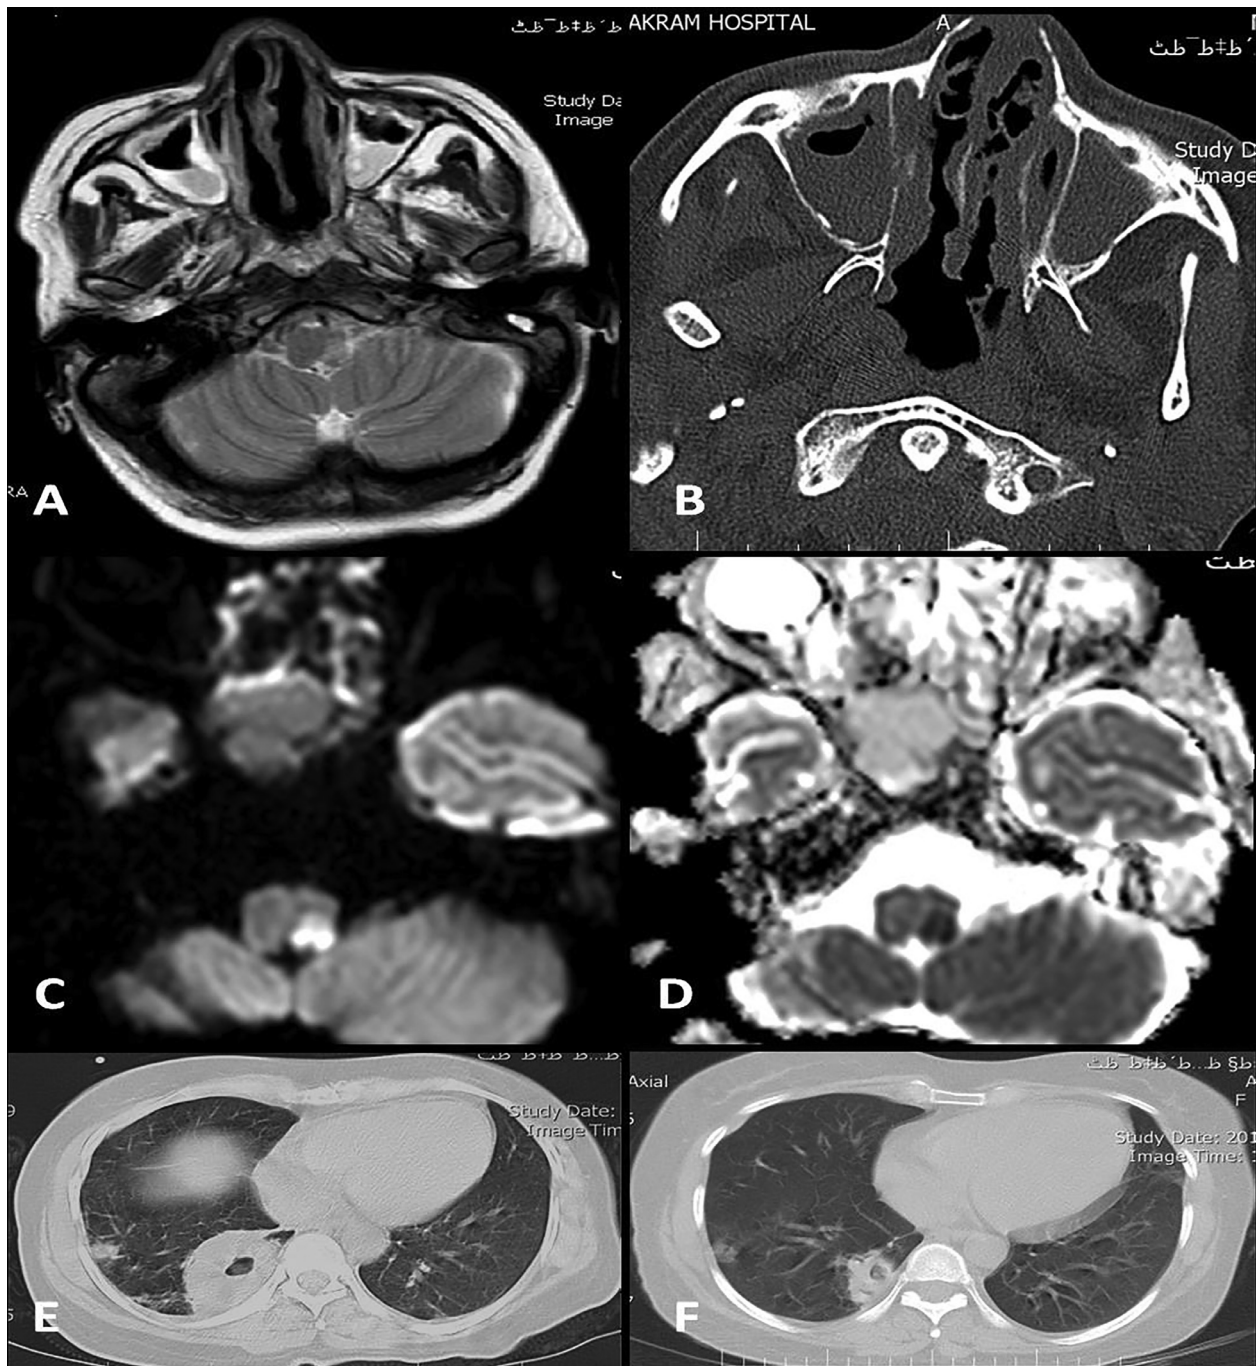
(A) Brain MRI, T2-hypersignal area in left lateral medulla and mucosal thickening and fullness of maxillary sinuses. (B) PNS-CT, severe sinusitis in paranasal sinuses. (C and D) Diffusion imaging restriction in favor of acute stroke. (E and F) Chest CT shows bilateral infiltrations and a mass-like lesion with cavitation in right lung before (left plane) and 6 month after (right plane) treatment. Abbreviation: MRI, magnetic resonance imaging; PNS-CT, paranasal sinuses computed tomography.
